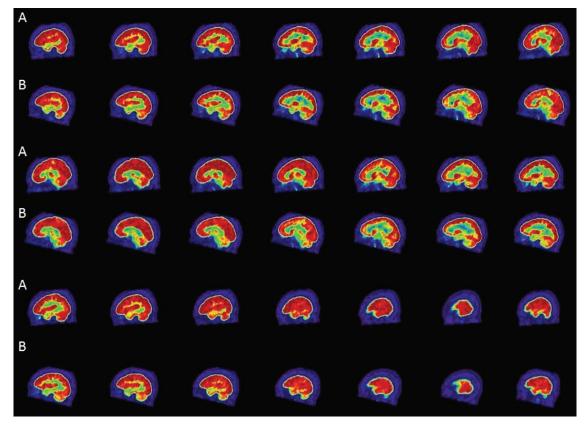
18-fluorine-flourodeoxyglucose-positron emission tomography (18F-FDG-PET) of a patient with zolpidem induced sleepwalking, sleep related eating disorder, and sleep-driving. A: 18F-FDG-PET off zolpidem. B: 18F-FDG-PET on zolpidem. FDG was administered to patient 1 h after ingestion of 10 mg zolpidem. Statistical parametric mapping comparison of the 2 sequences shows no significant differences.
